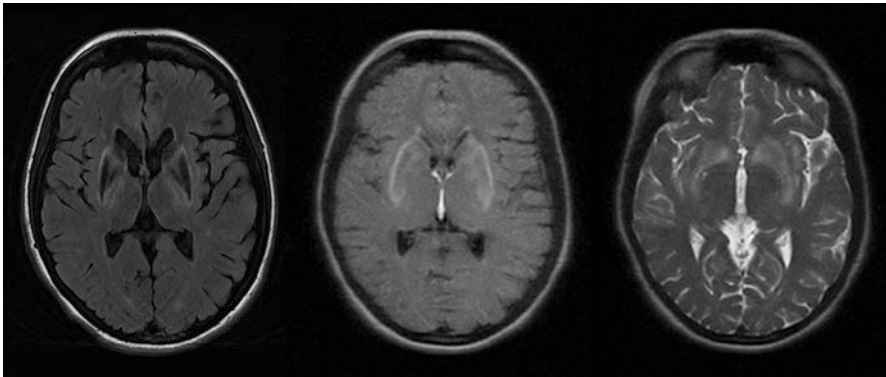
MRI of the brain of three different patients with Wilson's disease showing signal changes in basal ganglia on FLAIR and T2-weighted images
